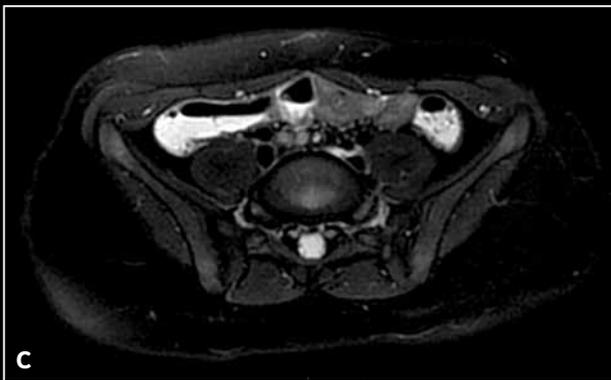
(A) Axial DWI, 4 mm, Respiratory Trigger, acquisition time of 5:07 min, b600; (B) pre-contrast LAVA Flex Axial; (C) PROPELLER T2 FatSat; (D) Fusion of the DWI to the LAVA Flex post contrast.
